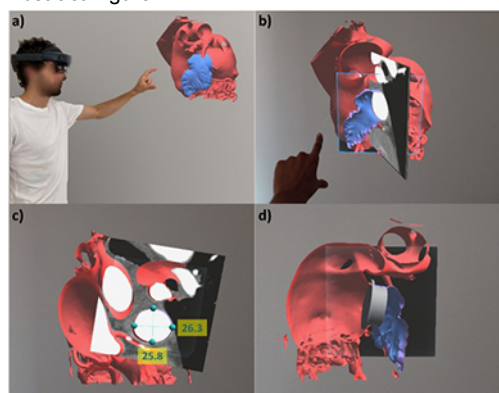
a) MxR application with a model of all the structures of interest displayed. b) Example of MxR interaction: cutting the model and visualization of a slice extracted from the CT volume overlaid on the 3D model. c) Example of the MxR measuring tool: measurement of the landing plane maximum and minimum diameters. d) Example of virtual implantation of the occluder device inside the MxR model.
